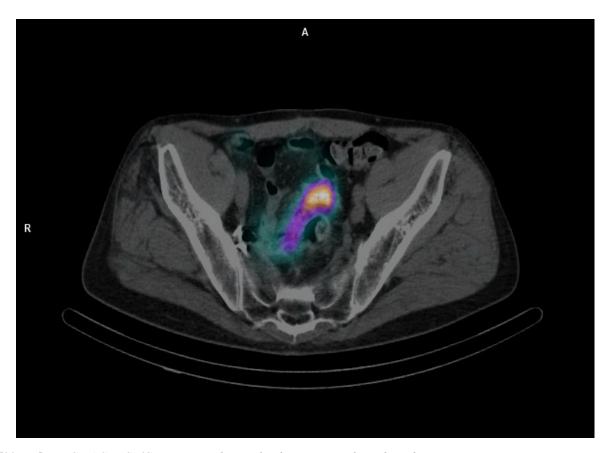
[99mTc] Tc-PSMA SPECT/CT scan revealing radiopharmaceutical uptake in lesion.
